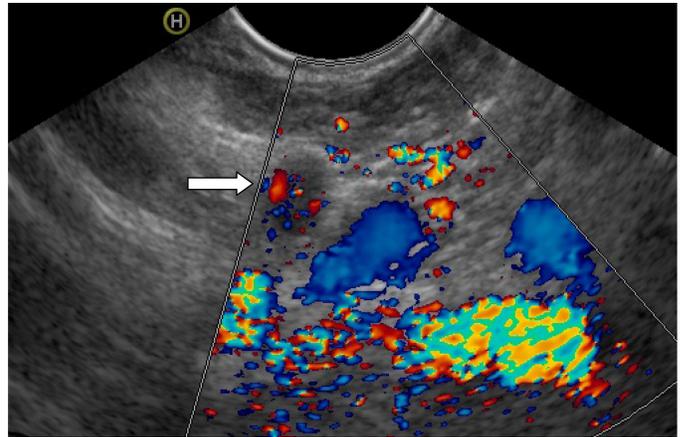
Linear EUS color doppler image showing no doppler flow in splenic artery (horizontal arrow) and normal flow in splenic vein.
